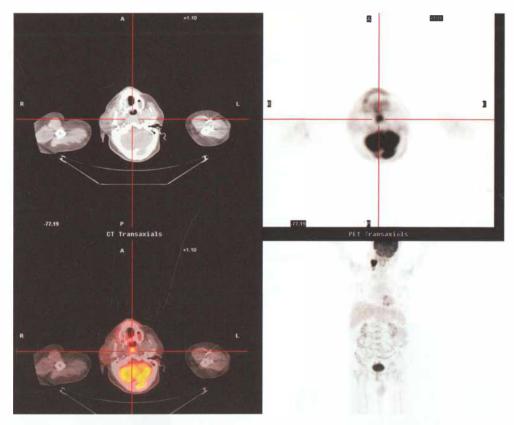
23: Carcinoma nasopharynx—PET-CT scan
